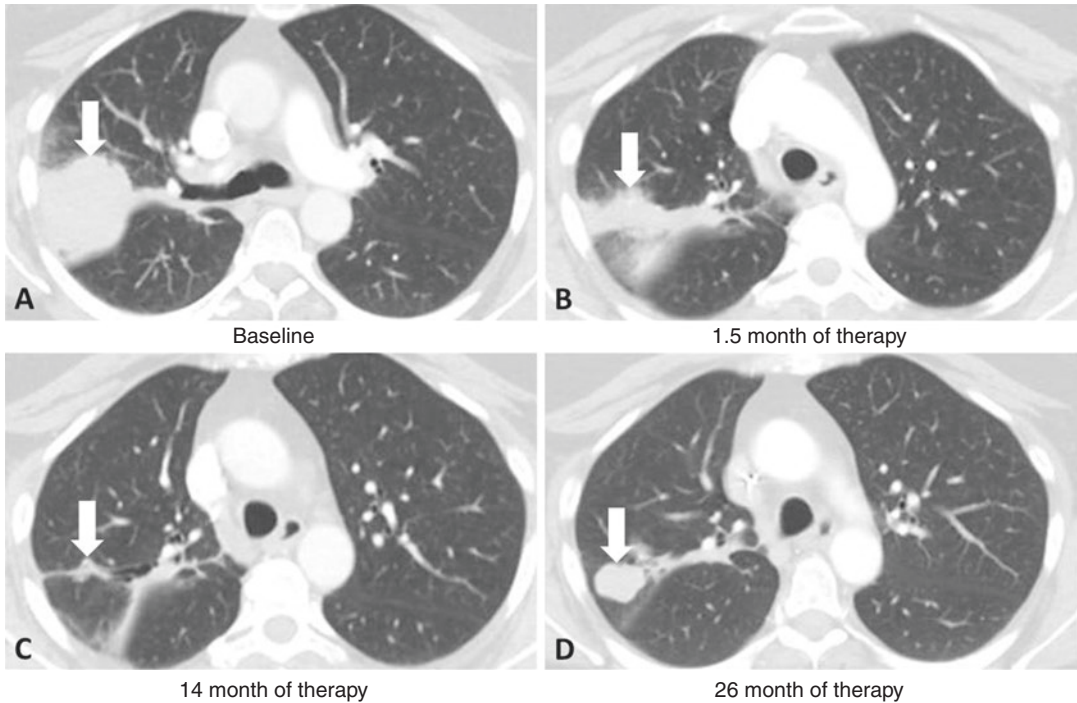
A patient with stage IV NSCLC with EGFR exon 19 deletion who progressed on erlotinib due to the development of T790M acquired resistance mutation, subsequently treated with osimertinib. (a) Baseline CT prior to osimertinib therapy showed a dominant mass (arrow) in the right upper lobe demonstrating tumor progression during erlotinib therapy. (b) At 1.5 months of osimertinib
